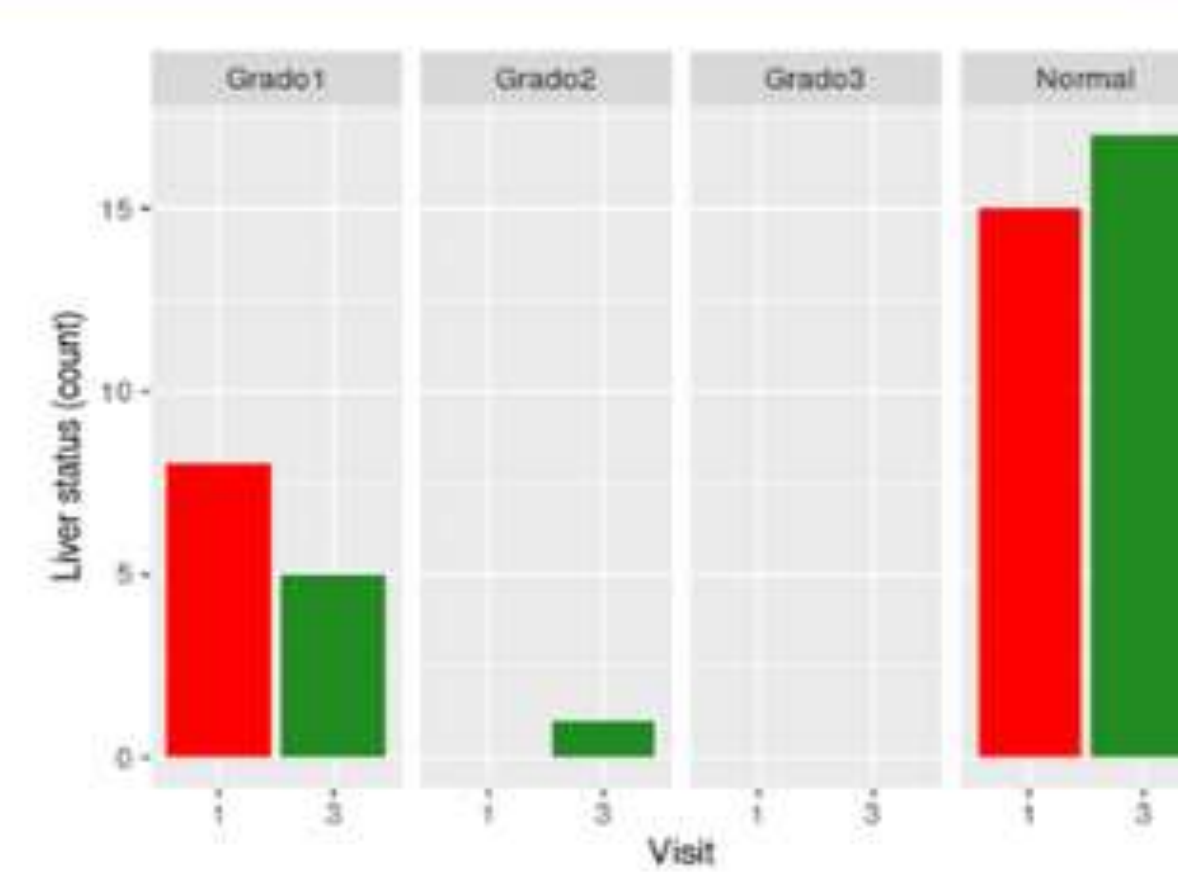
Ultrasound at baseline and at the end
